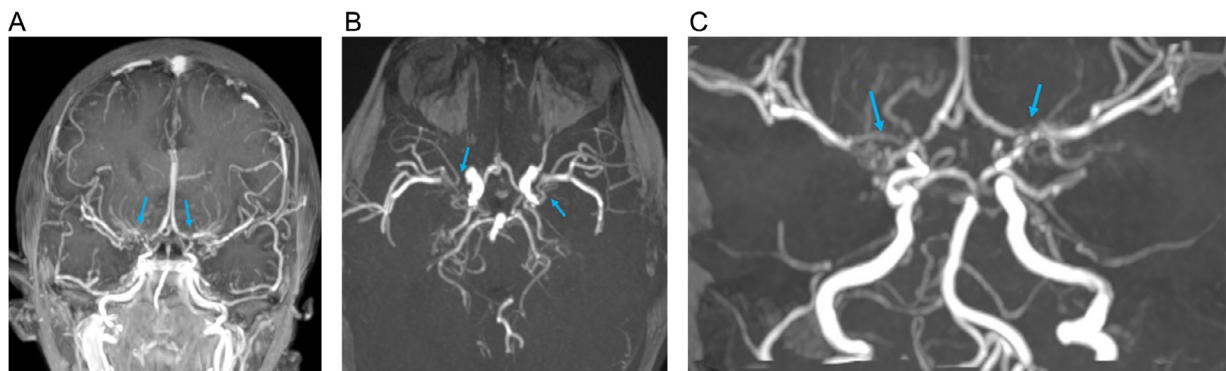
Brain MRI in T1 contrast-enhanced coronal sequence (Fig. A) and TOF sequences in axial (Fig. B) and coronal (Fig. C) views show severe stenosis of the terminal portions of the carotid arteries and the proximal portions of the middle cerebral arteries bilaterally, more pronounced on the right with hypertrophy of the adjacent perforating arteries creating a 'smoke-like' appearance (blue arrows).
